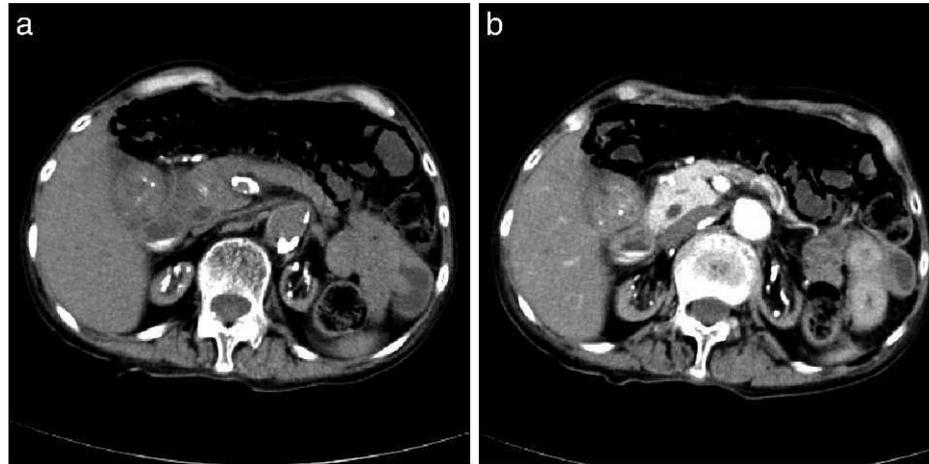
Plain computed tomography revealed irregular thickening of the whole wall of the gallbladder from body to bottom with tiny gallstones (a). The thickened wall was slightly enhanced by contrast medium (b).
